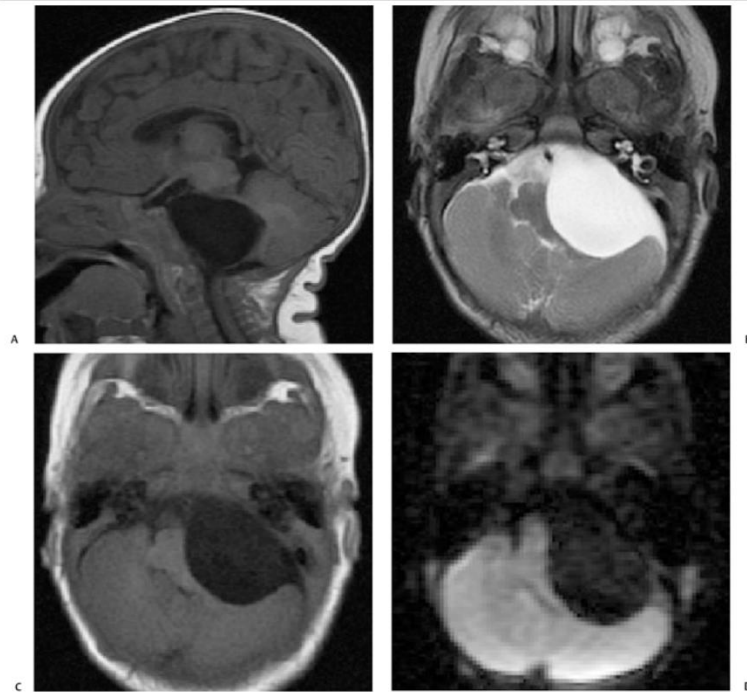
Cerebellopontine angle (CPA) arachnoid cyst. (A) Sagittal T1-weighted and (B) axial T2-weighted magnetic resonance images show a smoothly contoured fluid-intensity left CPA mass, which suppresses completely on axial fluid attenuated inversion recovery (FLAIR) imaging (C). No abnormal signal is seen in the adjacent medulla or left cerebellar hemisphere. (D) Axial diffusion-weighted image shows low signal intensity (no restricted diffusion), confirming the cerebrospinal fluid/fluid nature of this mass. Despite significant local mass effect, there is no obstructive hydrocephalus in this child who presented with macrocrania and head tilt. (Courtesy of Gary Hedlund, MD.)
